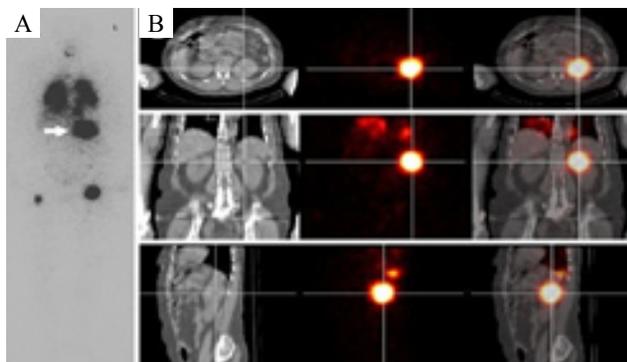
A patient with a history of FTC presented with lungs metastases and received ^{131}I treatment. Posttherapeutic ^{131}I -WBS images demonstrated bilateral lungs ^{131}I uptake. An additional area of high focal tracer uptake was noted in the left upper quadrant (A, arrow), which was initially thought to be related to the bowel. This was further evaluated with ^{131}I -SPET/CT and a lesion localized in the left kidney was revealed (B). The activities projected over the lower limbs were bone metastases.
